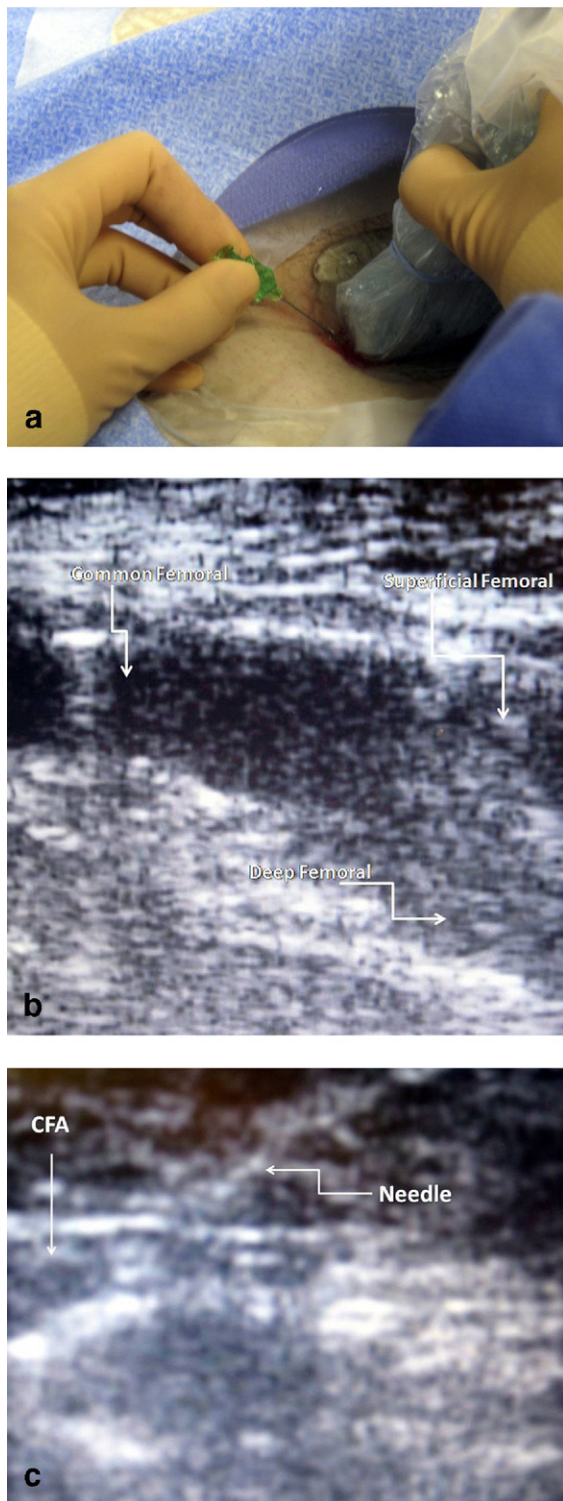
Ultrasound scan-guided femoral arterial access is performed by one operator. In this example, the right hand controls the ultrasound probe (a) to image the common femoral artery just proximal to the femoral bifurcation (b). The left hand punctures the artery with the access needle, which can be seen as it enters the common femoral artery (c).
